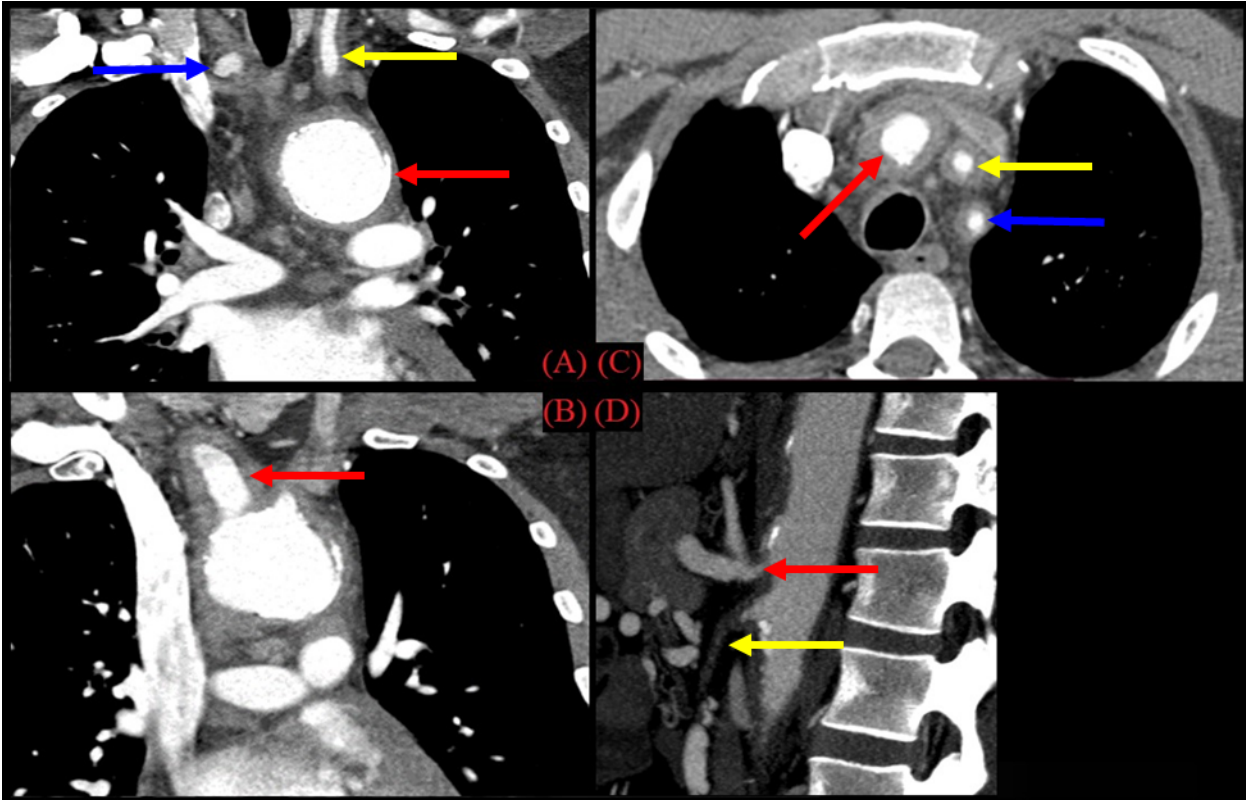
CT Angiogram. A) Aortic arc ectasia (red arrow) with occluded right brachiocephalic artery lacking contrast (blue arrow) and thickening of the left common carotid (blue arrow); B) ectasia and thickening of the right brachiocephalic artery (red arrow) with nearly 30% right subclavian artery stenosis; C) circumferential thickening of the origin of the left brachiocephalic (red arrow), left common carotid (yellow arrow), and left subclavian (blue arrow) arteries; D) near 75% celiac axis origin stenosis (red arrow) with occluded celiac axis (yellow arrow).
